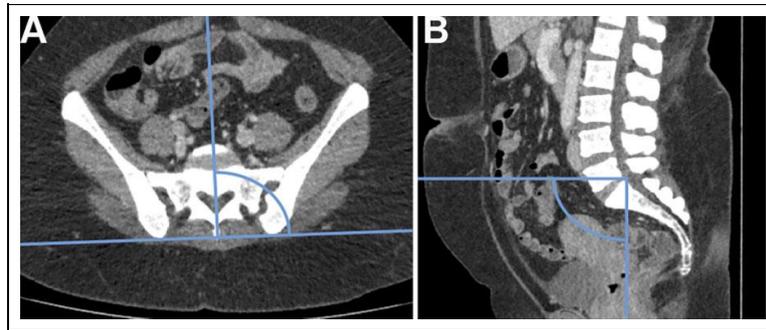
In (A) an axial CT image is shown, in which the line connecting the 2 spinae iliacae posteriores superiores and the orthogonal line defining 0° axial angulation are highlighted. In (B) a sagittal CT image is shown. A line parallel to the CT table and a line orthogonal to it defining 0° sagittal angulation are depicted. The intersection of the 2 lines was placed on each predefined screw entry point for screw placement.
